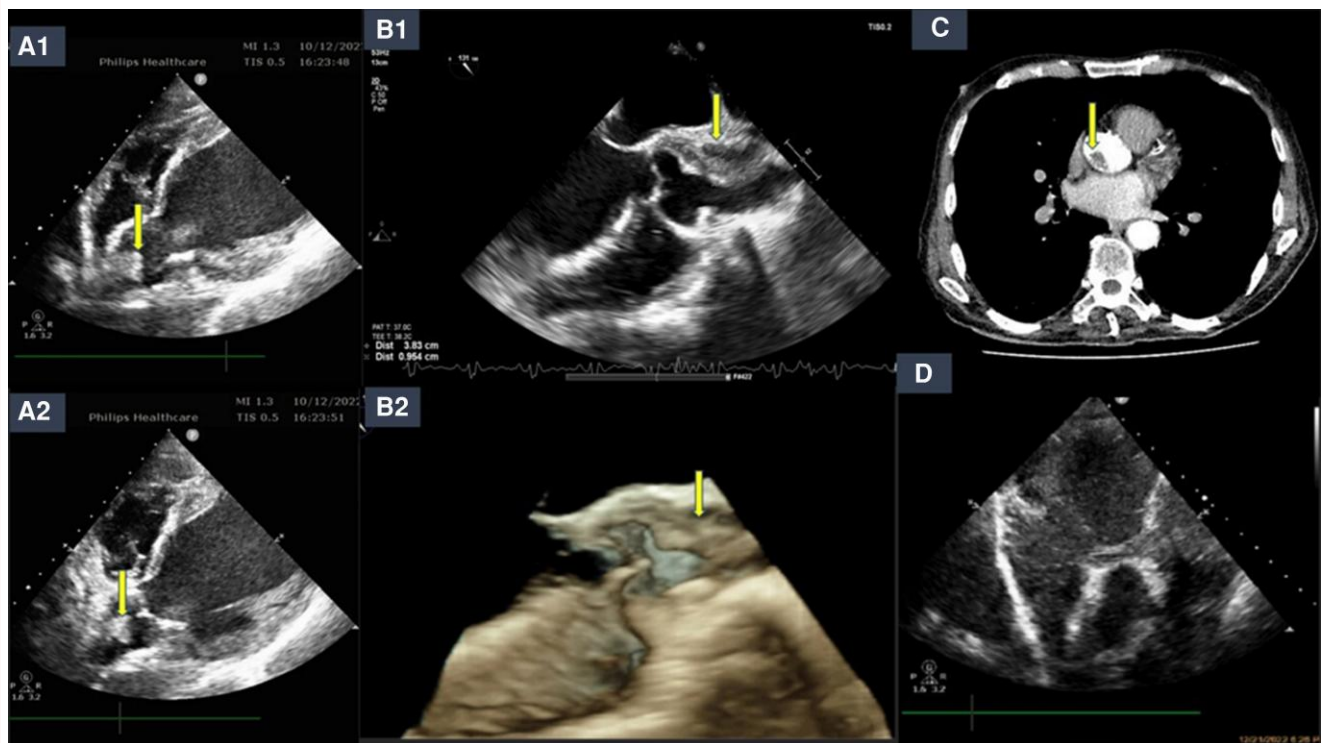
Panel A1–A2: transthoracic echo (subcostal view) showing the aortic thrombus in the aortic root first diagnosis, Panel B1: transoesophageal echo (mesoesophageal long axis view) showing 3,83 cm length thrombus rising from the left sinus of Valsava, Panel B2: transoesophageal 3D echo (mesoesophageal long axis view) Panel C: computed tomographic angiography confirming the presents of thrombus in Aorta, Panel D: emergent transthoracic echo (subcostal view) during cardiopulmonary resuscitation reveals that the thrombus had been detached.
